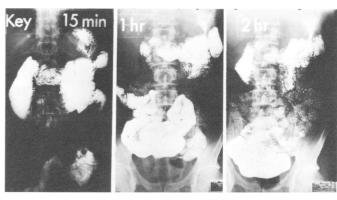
Following transthoracic vagotomy, pouch ulcer healed with residual narrowing. Because of abdominal discomfort and fullness, patient is considered to have poor result.
